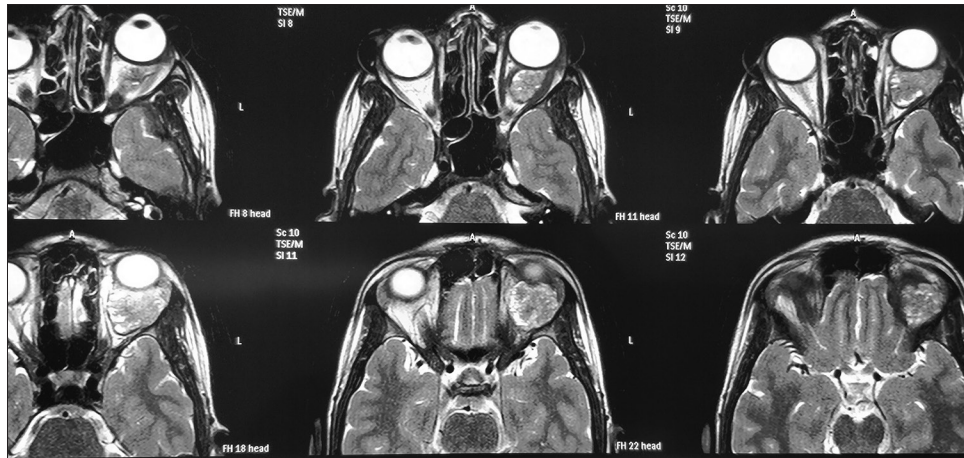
Magnetic resonance imaging T2-weighted axial images – hyperintense lesion involving extraconal as well as intraconal compartment of the left eye
